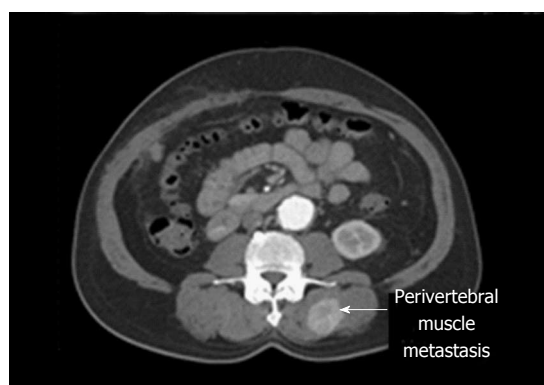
Computed tomography of the recurrent tumor. Computed tomography scan showing an enhancing lesion 3.7 cm in size in the left paravertebral musculature.
